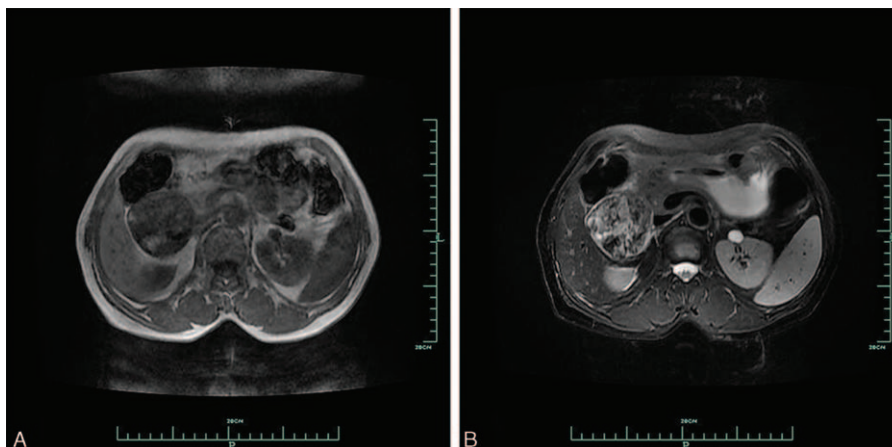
On magnetic resonance imaging, the mass appeared hypointense on T1-weighted images (arrow) (A) and inhomogeneous hyperintense on T2-weighted images (arrow) (B).
